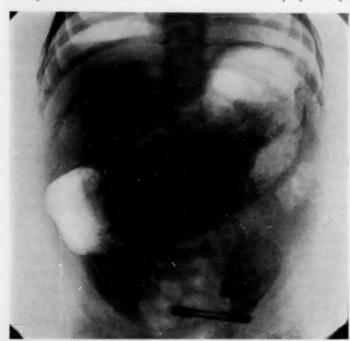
Stomach: Fluoroscopic and radiographic examinations. A thin solution of malted milk containing barium sulphate was administered. The child could only retain about one ounce. The solution was observed to drop into what appeared to be a dilated stomach. The radiographs demonstrated a stomach dilated to more than twice the normal size. The outlines of the lesser and greater curvatures were quite regular, the pyloric end of the stomach ending up rather bluntly but evenly. The pylorus was not outlined nor was the duodenum demonstrated. No barium was observed to enter the small intestine. Conclusion: There is presented a markedly dilated stomach which is secondary to some form of benign stenosis of the pylorus.
